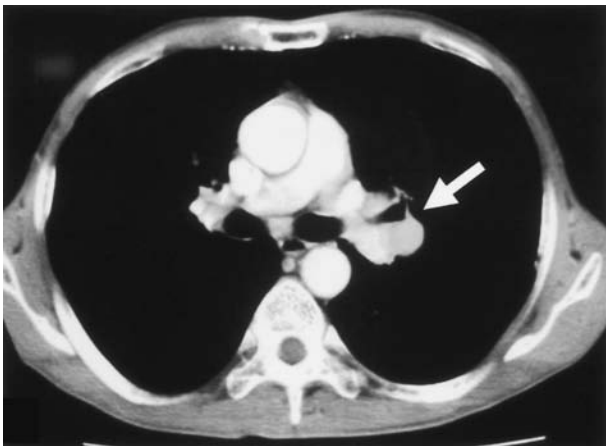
CT image of the chest (contrast-enhanced). The tumor (arrow) has a regular, smooth, and poorly enhanced margin. The tumor compresses the left primary bronchus and left pulmonary artery but has not invaded. No lesions nor mediastinal lymphadenopathy were observed in the lung field.
